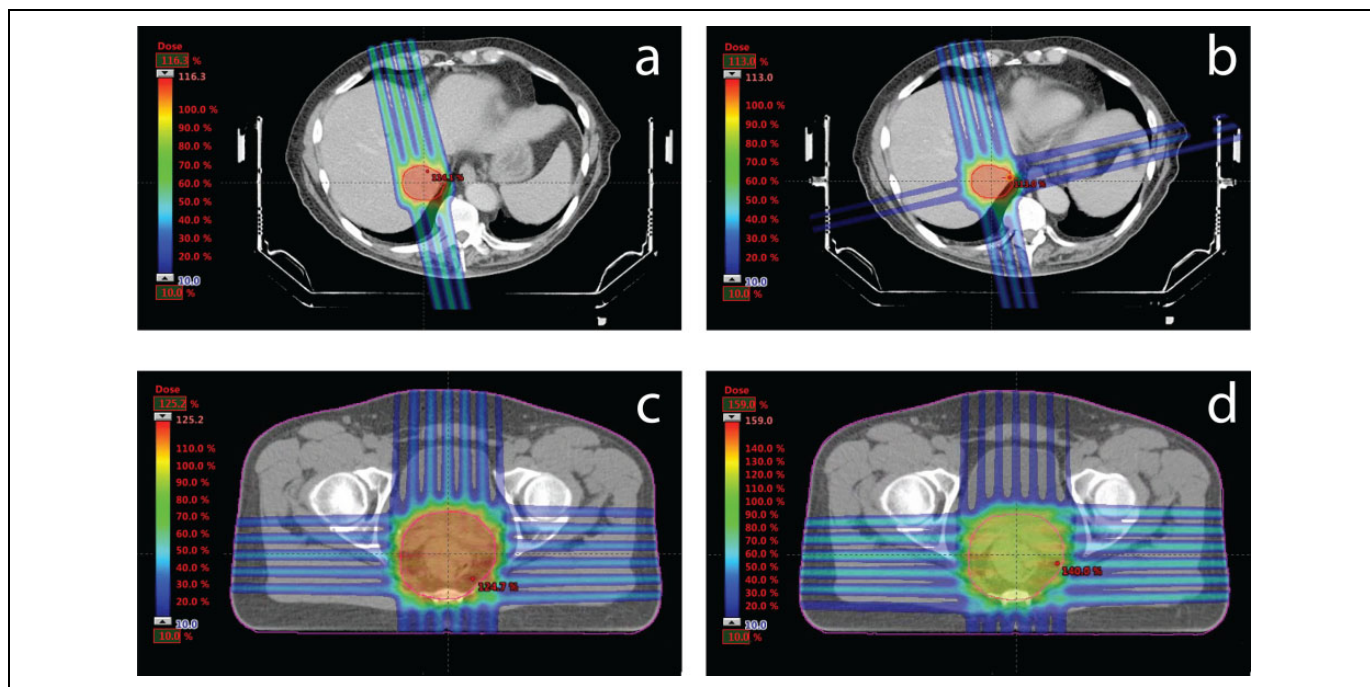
Planned dose distributions obtained for the grid irradiations superimposed on axial computed tomography (CT) sections from the 2 patient cases studied: (A) liver cancer, 2 opposing 1-dimensional (1-D) grids, (B) liver cancer, 2×2 opposing 1-D grids (C) rectal cancer, 2×2 opposing 1-D grids, and (D) rectal cancer, 2×2 opposing 2-dimensional (2-D) grids. CT indicates computed tomography; 1-D, 1-dimensional; 2-D, 2-dimensional.
